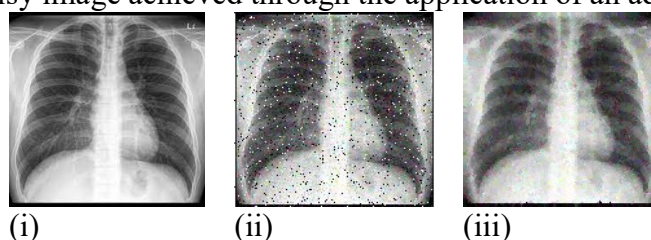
Column (i) displays the initial chest X-ray image. In column (ii), the image is presented with 20% noise added. Column (iii) demonstrates the application of the adaptive median filter for denoising the image.
